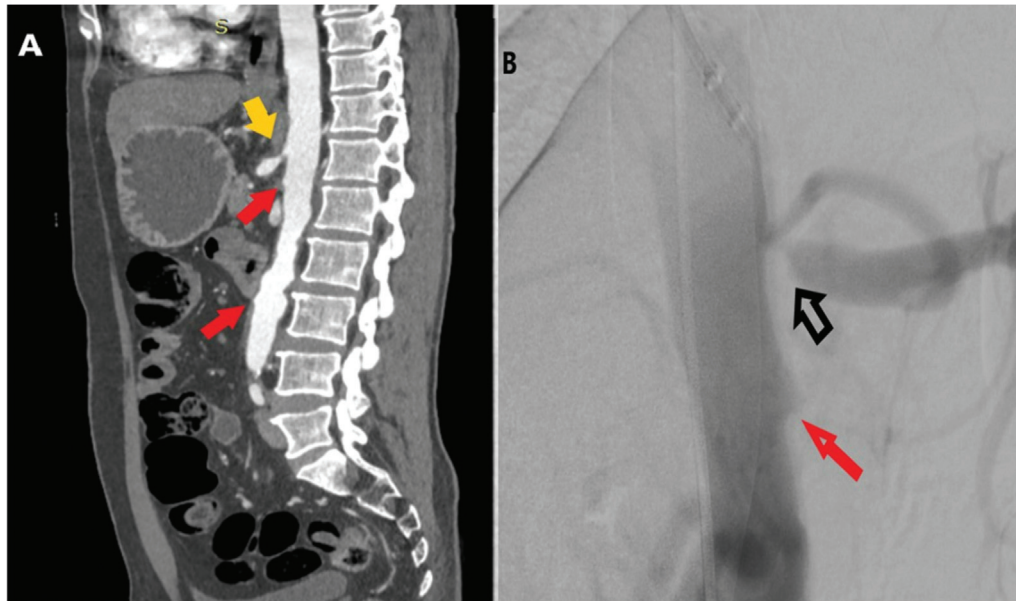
(A) Computed tomography sagittal section showing 90% stenosis of celiac trunk (yellow arrow) with complete occlusion of superior mesenteric artery (SMA) and inferior mesenteric artery (red arrow). (B) Digital subtraction angiography lateral view showing 90% stenosis of celiac trunk (black arrow) with complete occlusion of SMA (red arrow).
